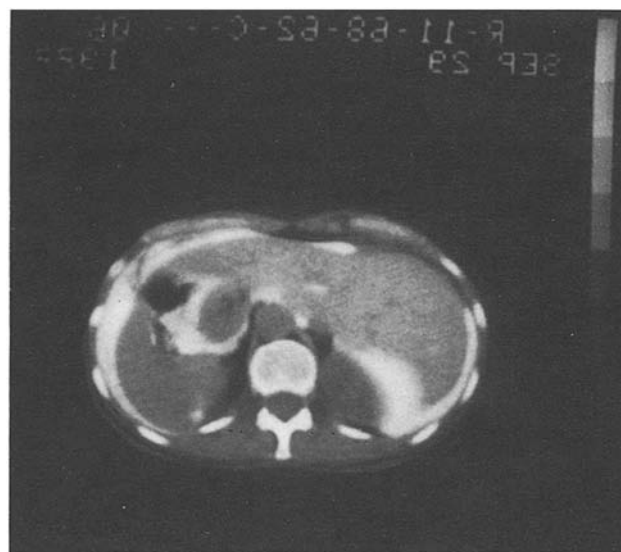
Intraperitoneally computed tomogram following installation of iodinated contrast media (white)
